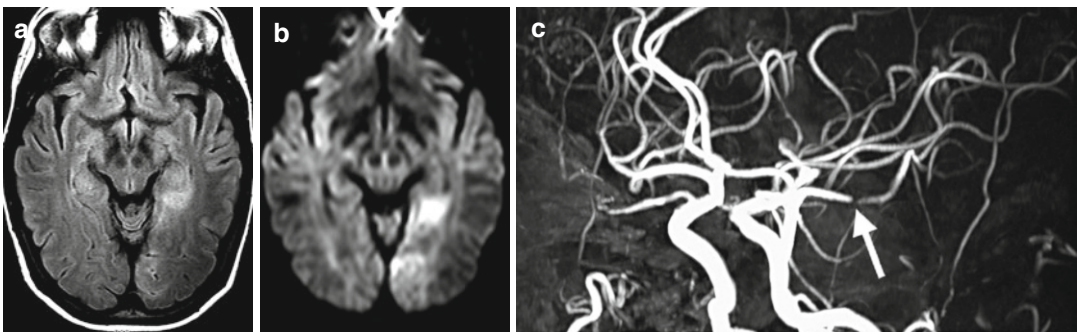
Acute infarct in the distribution of the left posterior cerebral artery. Clinical findings: Sudden onset of right homonym hemianopia in a pregnant woman at 35th week of gestation. There is high signal on FLAIR and diffusion weighted images. Restricted diffusion refers to a cytotoxic edema. MRI angiography indicated significant stenosis of the left posterior cerebral artery. (a) FLAIR (b) DWI (c) MRI angiography
